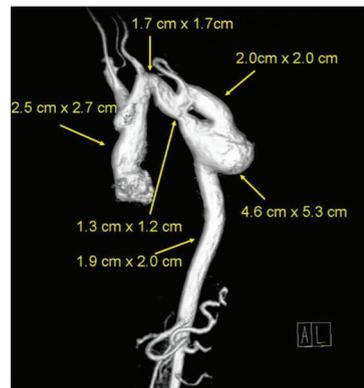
Pre-operative MRI of aortic anatomy.
